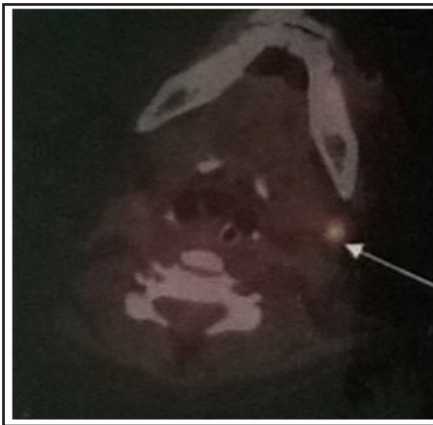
Cervical Level II lymph node showing FDG avid uptake
